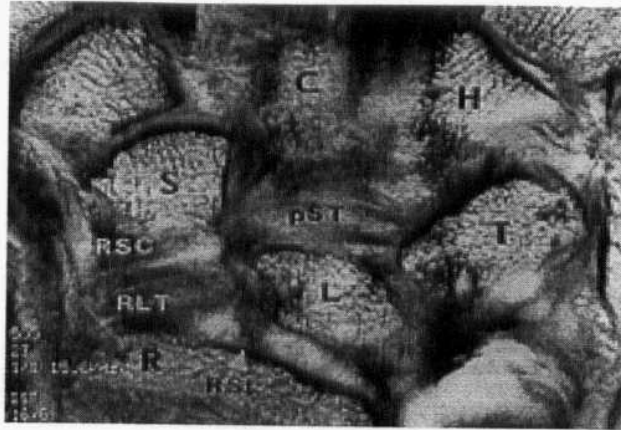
Coronal T1-weighted spin-echo MR arthrographic image demonstrates Palmar radiocarpal and intercarpal ligaments. the capitate (*C*) , The palmar scaphotriquetral ligament (*pST*), scaphoid (*S*), triquetrum (*T*), radioscapholunate (*RSL*),. The long radiolunate (*RLT*) and radioscaphocapitate (*RSC*) (Quoted from Theuman 2002).
